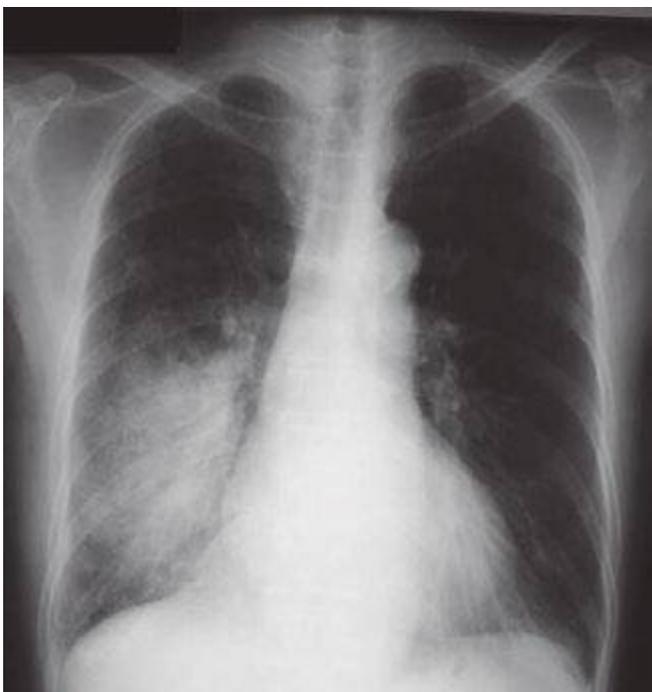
Chest radiograph depicting classic lobar pneumococcal pneumonia in the right lower lobe of an elderly patient's lung.
